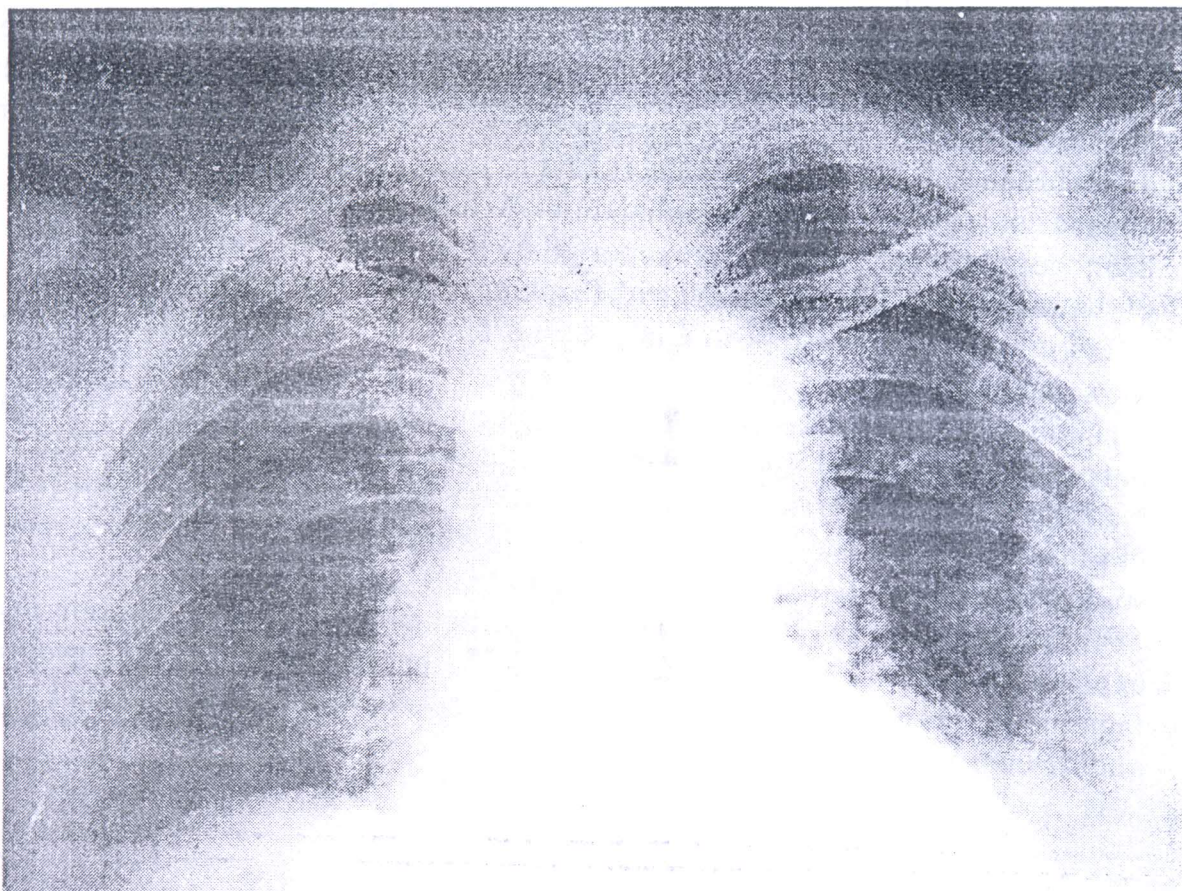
Chest X-ray showing reticulo nodular shadow in both lungs suggesting interstitial lung disease in a patient of arsenicosis.
